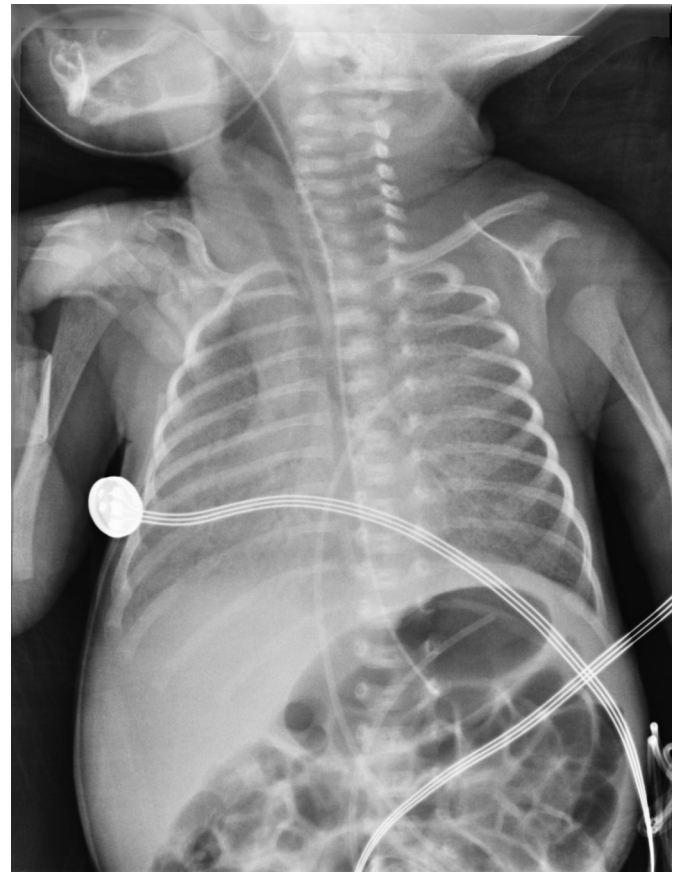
Plain radiograph with proper placement of OG tube.
